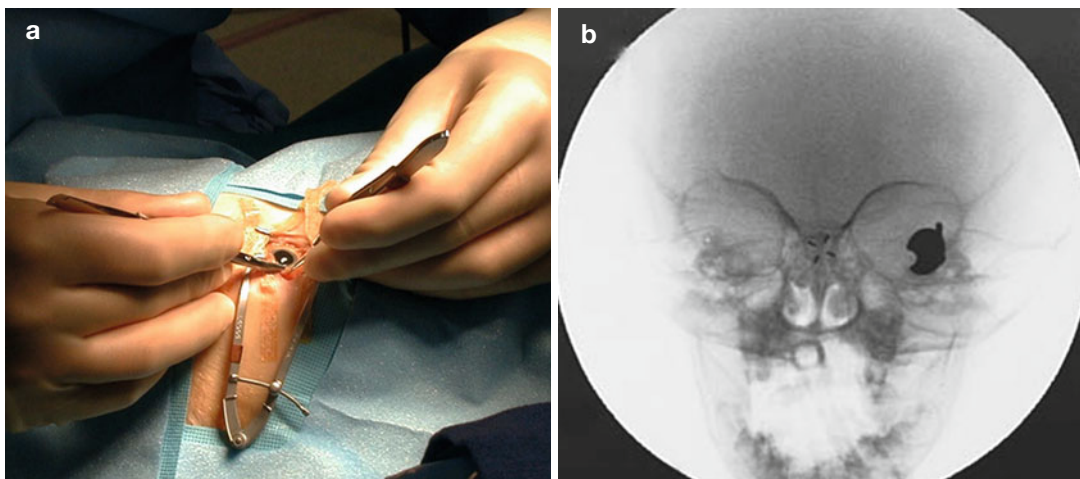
Application of a notched episcleral iodine-125 plaque for brachytherapy (a). The corresponding x-ray image showing the episcleral plaque, abutting the optic nerve (b)
